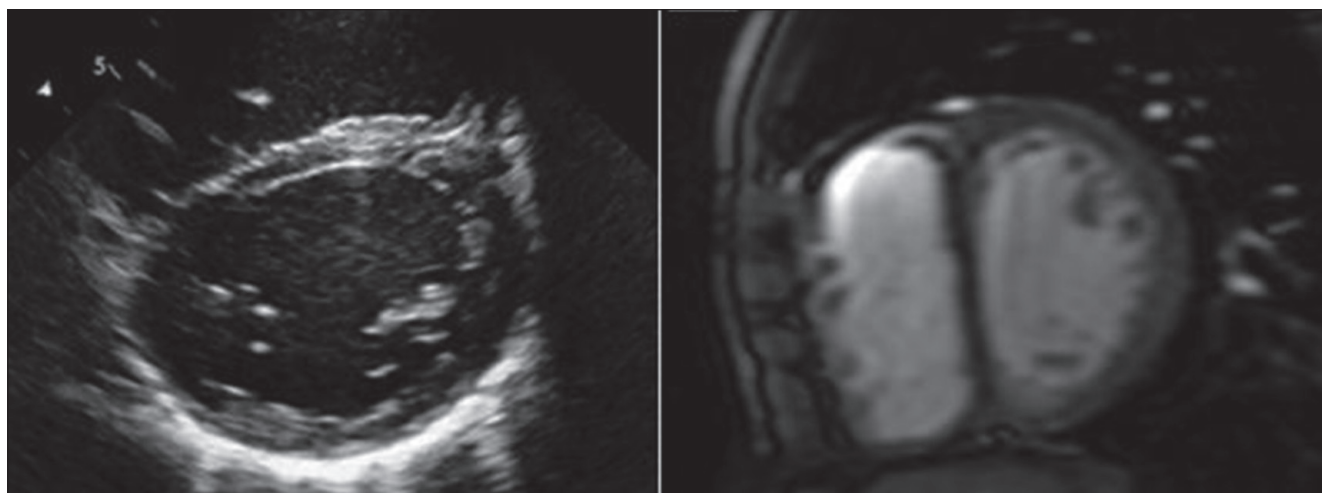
Short-axis echocardiogram image at the level of the left ventricles and MRI in the same view performed at 9 years of age, where the left ventricular morphology can be seen one year after anatomical correction.
